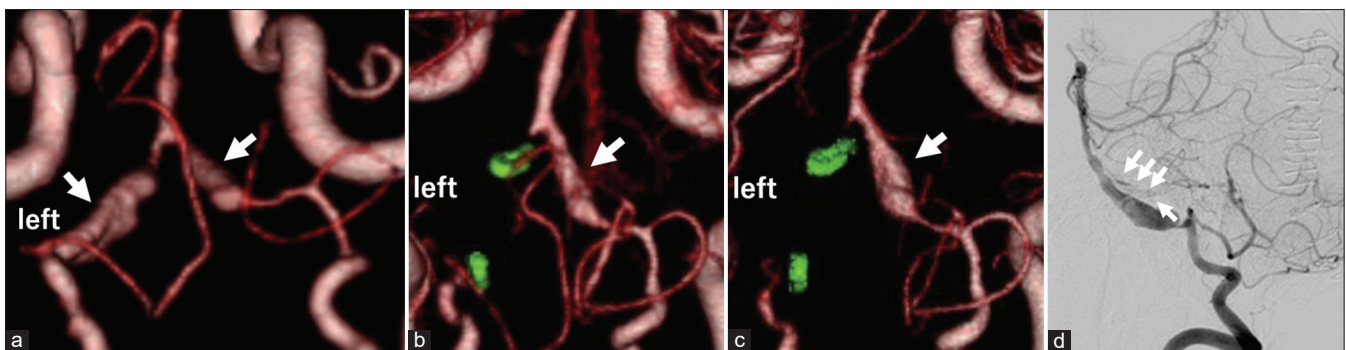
(a) Posterior view of computed tomography angiography on admission demonstrates bilateral vertebral dissection aneurysm (arrows); (b) Posterior view of computed tomography angiography on hospital days 3 (arrows); (c) Posterior view of computed tomography angiography on hospital days 11 reveals that the right vertebral dissection aneurysm is rapidly enlarging (arrows); (d) A lateral view of right vertebral angiography reveals a perforating artery to the medulla oblongata from the distal part of the right vertebral dissection aneurysm (arrows) and hypoplastic precommunicating segment of the posterior cerebral arteries.
